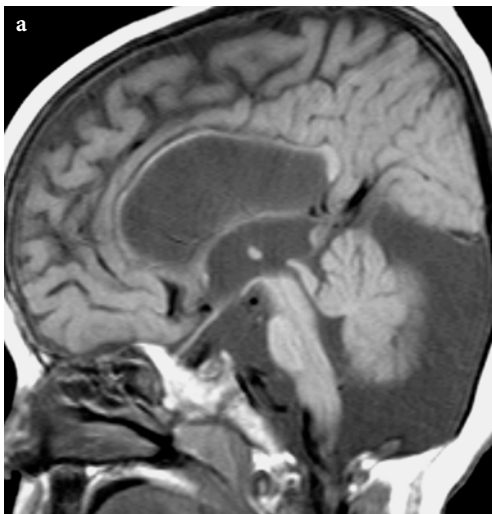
Conventional MR imaging findings in a 3-year-old male patient with pyruvate dehydrogenase deficiency. a Sagittal T1-weighted spin-echo image shows atrophy of cerebellar vermis and an incidental mega cisterna magna. b–d Axial T2-weighted fast spin-echo images. Prominent enlargement of the ventricular system. Subtle, patchy hyperintensities within the right putamen. Abnormal hyperintense appearance of the cerebral white matter, indicating demyelination and/or transependymal CSF permeation. Note partial sparing of subcortical U-fibers in the frontal regions
